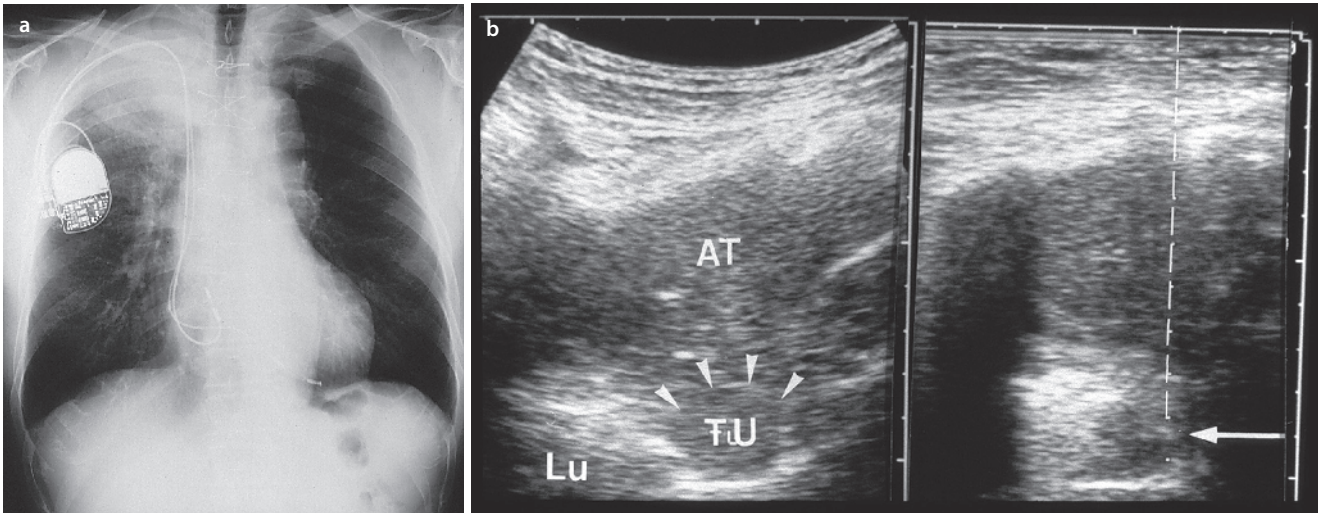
A 67-year-old man with a bronchial carcinoma. a Chest X-ray: shadow in the region of the upper field on the right side. b Sonography: right-ventral echo transmission shows a small central tumor (TU) on the left with subsequent atelectasis (AT). The tumor
